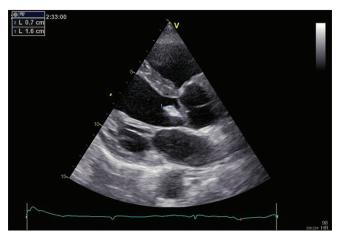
Transthoracic echocardiogram showing an aortic valve vegetation measuring 7 mm imes 16 mm
